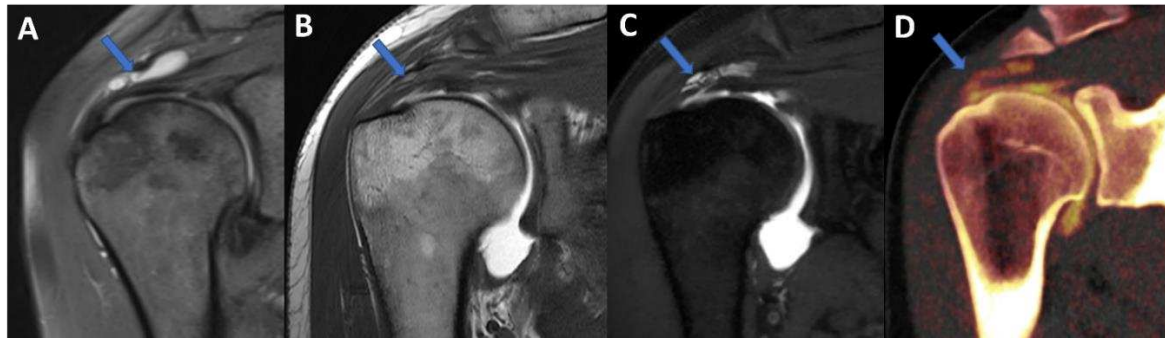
Complete supraspinatus tendon diagnosed on DECTA. On Coronal standard STIR MRI image (A), a fluid collection located on the bursal side of supraspinatus tendon can be recognized (arrow). On Coronal T1-weighted TSE MRA image (B), the supraspinatus tendon appears irregularly thinned, as in a case of partial tear. There is no apparent passage on contrast material on the bursal side (arrow). On the corresponding 1 mm PD fat saturated image on coronal plane (C) there are still no clear signs of complete tendon tears (arrow). The reconstructed DECTA 1 mm coronal image (iodine map; D) clearly demonstrates the presence of a complete tear with the passage of contrast material on the bursal side of the tendon (arrow).
